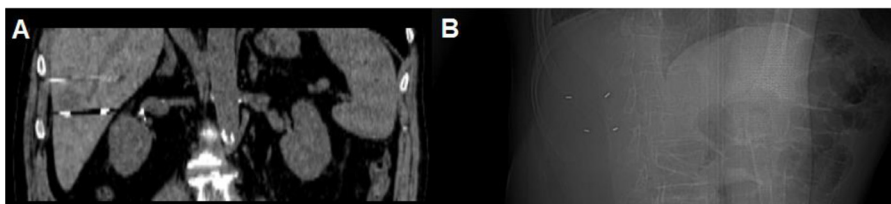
Fiducial markers placed in the liver lesion when using (A) computerized tomography scan or (B) 2-dimensional in-room X-rays.
